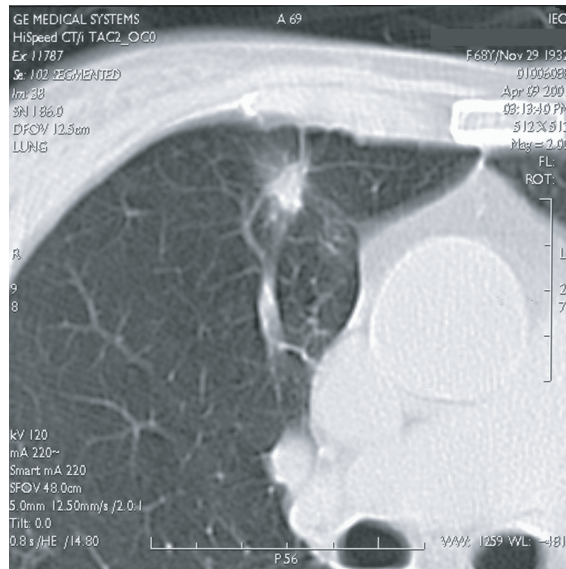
A 12 mm solid nodule with suspicious CT appearance, but negative at contrast enhancement study, was PET positive. Surgical biopsy revealed pulmonary fibrosis with lymphocytic reaction.
